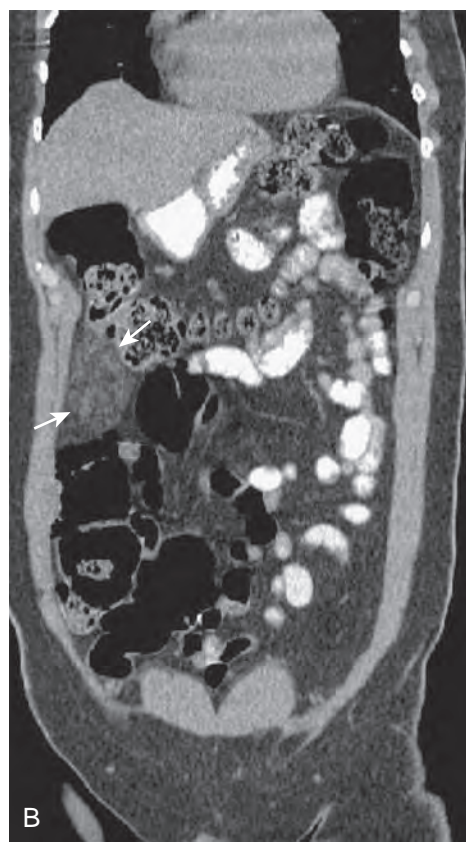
Mesenteric adenitis: CT features. Coronal reformatted image shows multiple, borderline, enlarged lymph nodes (arrows) in the ileocolic mesentery.
